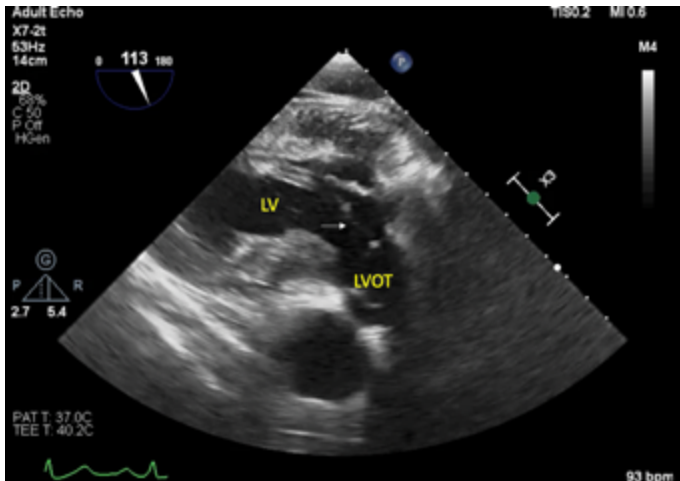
Accessory mitral valve tissue (white arrow) extending into the LVOT without systolic anterior motion transesophageal echocardiography transgastric view (LV, Left Ventricle; LVOT, Left Ventricular Outflow Tract).
